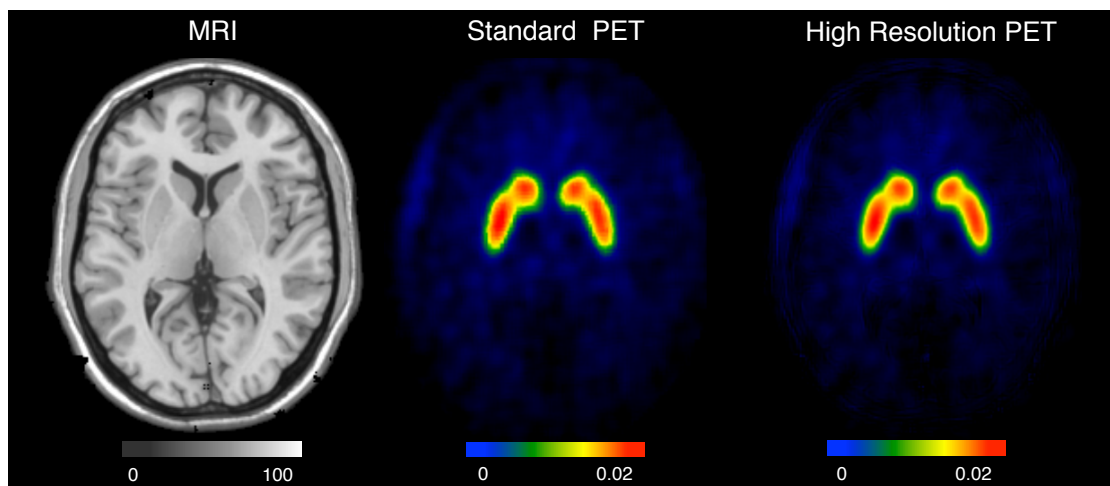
Axial view from a representative control subject of a $[^{18}\text{F}]\text{FDOPA}$ PET/MR dataset. Left column MRI image; central column Standard PET; right column High Resolution PET
